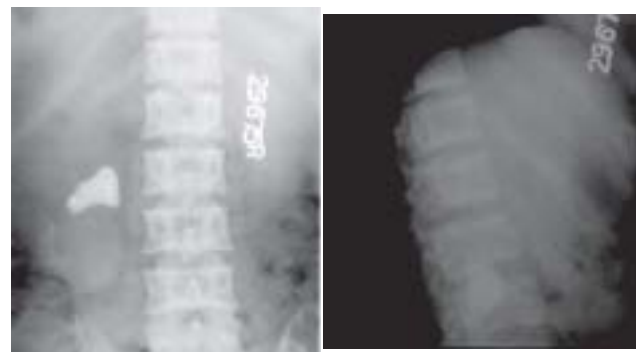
A & B: Plain abdominal radiograph AP view(A) showing a densely calcified left renal stone and the lateral film(B) showing the calculus to lie posteriorly overlying the spine.
